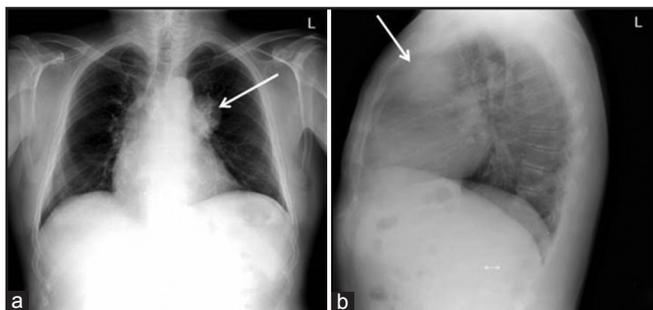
a. Chest radiograph in the anterior posterior (AP) view: infiltration in the upper anterior mediastinum (marked by the arrow) b. Chest radiograph in the profile view: infiltration in the upper anterior mediastinum (marked by the arrow)
